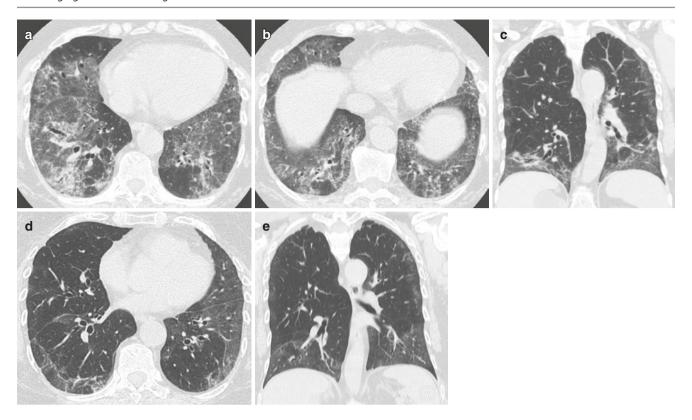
Antisynthetase syndrome. (a–c) Axial and coronal CT images show GGOs and traction bronchiectasis with NSIP pattern with mild OP. (d, e) Follow-up CT images after 6 months of steroid treatment show improvement in GGOs and scarring
